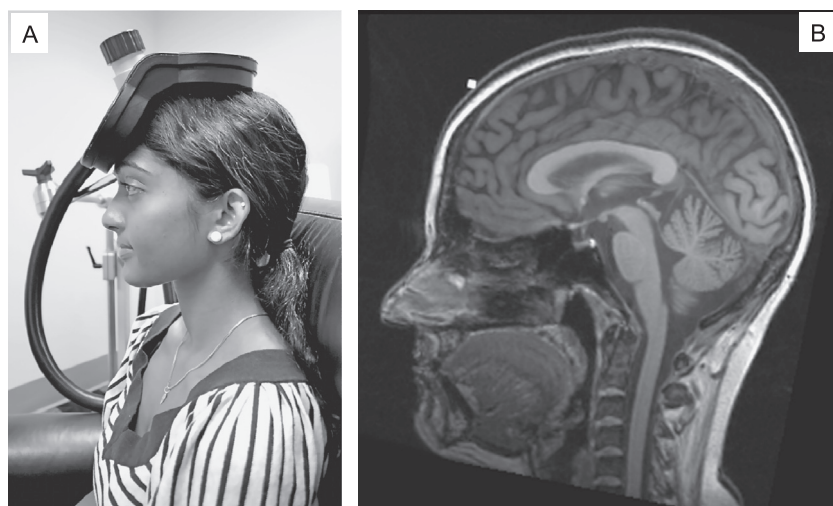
(A) Demonstration of placement of repetitive transcranial magnetic stimulation coil for dorsomedial prefrontal cortex stimulation with orientation of current flow to achieve preferential stimulation of the left hemisphere. In this series, 3000 pulses of 10 Hz stimulation at 120% resting motor threshold were applied to left then right hemisphere at each session. (B) T1 anatomical magnetic resonance imaging scan with small white square indicating the positioning of the coil vertex in a representative subject. To achieve dorsomedial prefrontal cortex coverage, the coil was placed at a scalp location corresponding to the Talairach coordinate (x 0, y +60, z +60), corresponding to ~25% of the nasion-inion distance.
